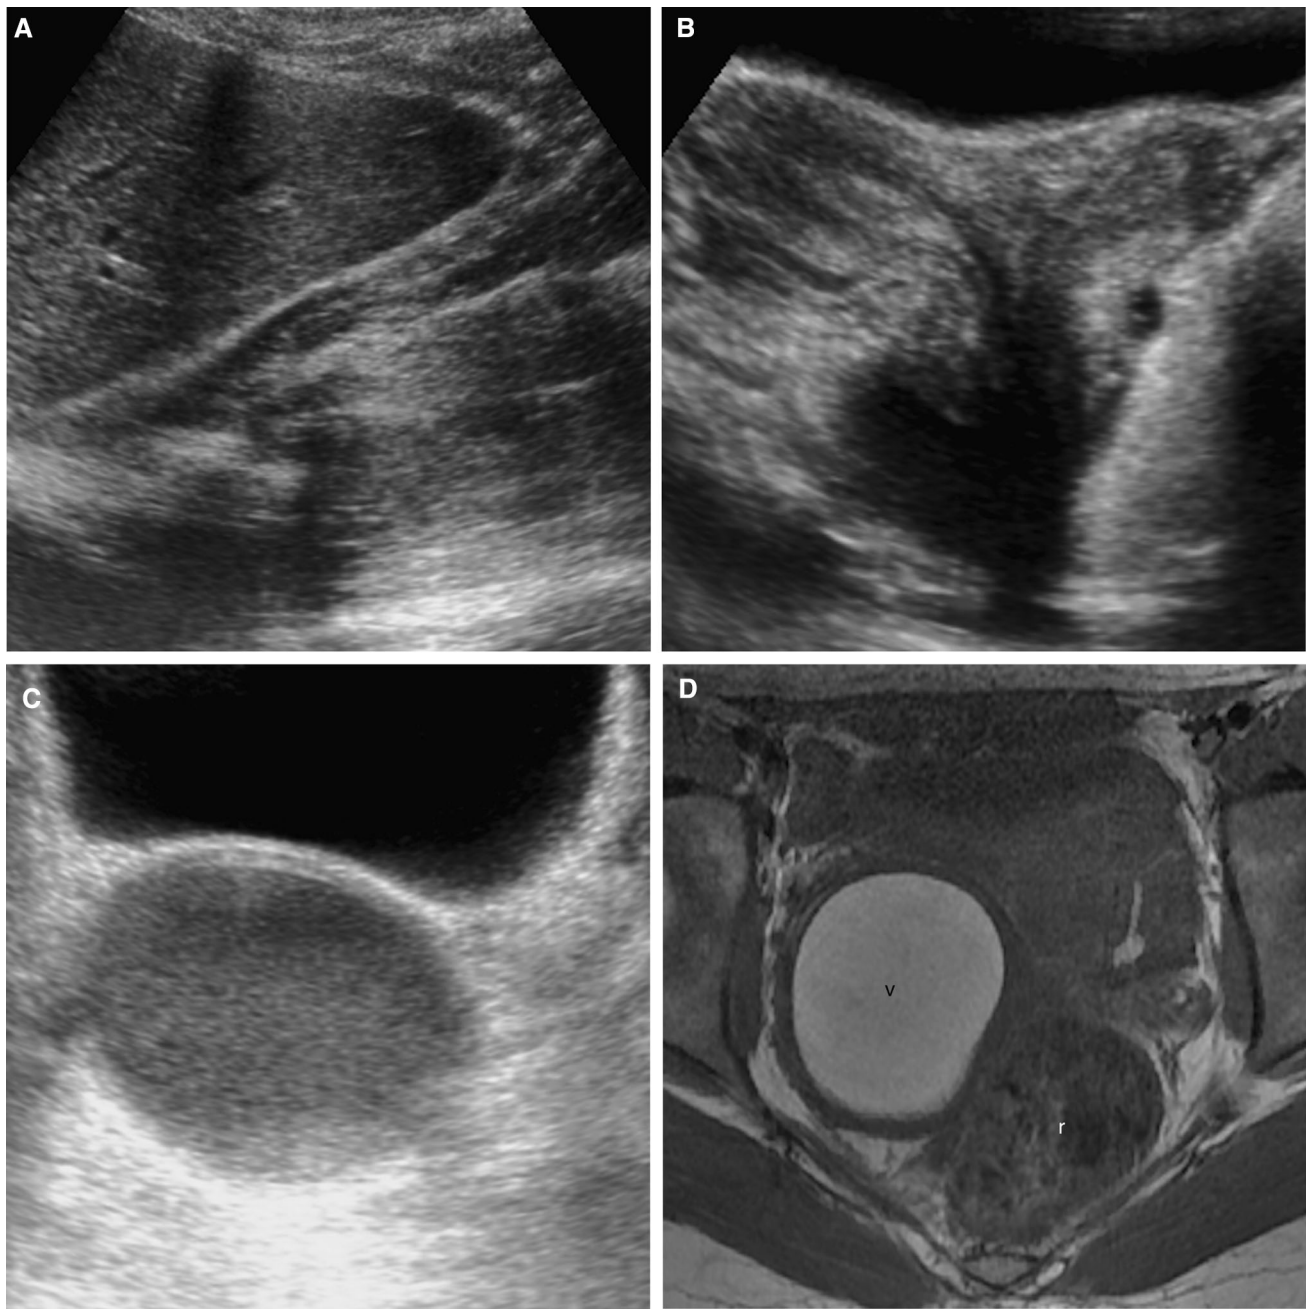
Images in a 13-year-old girl who presented to the emergency department with a 3-month history of dysmenorrhea (A–C US; D axial T1WI; E axial T2WI; F, G coronal T2WI; H sagittal T2WI). US revealed the absence of the right kidney (A), two uterine horns (B), and a dilated round cavity with homogenous, hypoechogenic content, and posterior enhancement (C). MRI was performed, showing a dilated right hemivagina with hematic content (*v*), hyperintense on T1WI (D) and hypointense on T2WI (E–H). Two uterine horns (F *arrows*) and two cervixes (G *dashed arrow*) are clearly depicted. These findings are compatible with uterus didelphys
